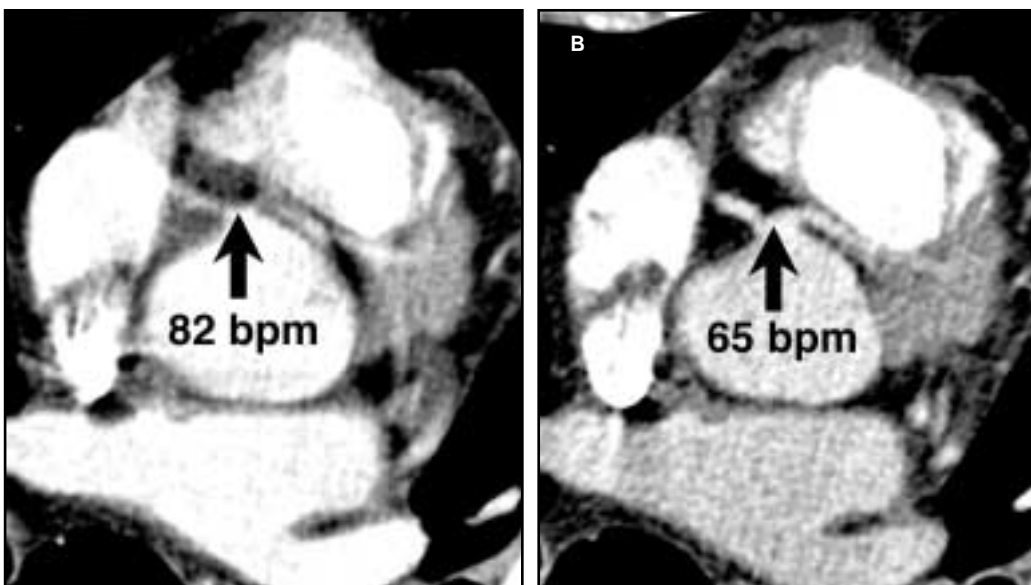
After intravenous beta blockers reduced the heart rate from (A) 82 bpm to (B) 65 bpm, CTA clearly depicts the coronary anatomy, including the common trunk of the left main coronary artery (arrows), originating together with the right coronary artery from the ostium of the right coronary artery.
